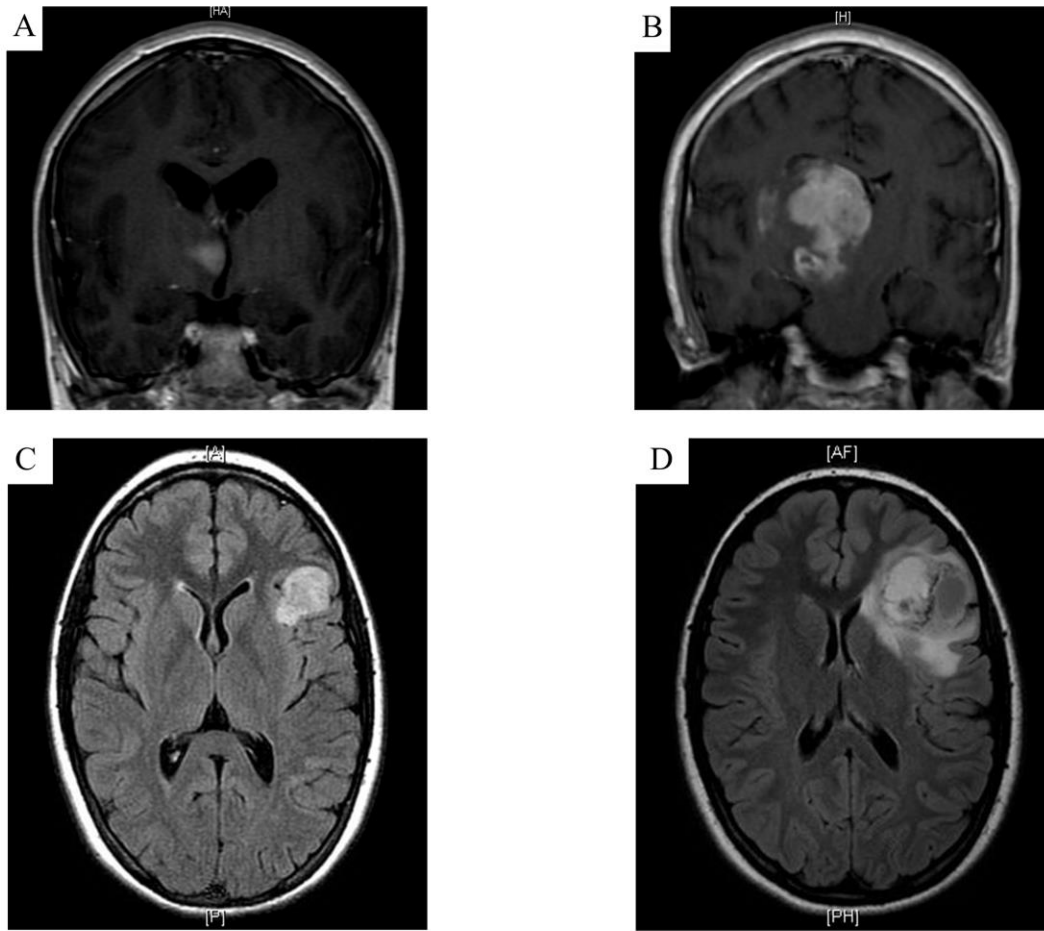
Radiological diagnosis of glioma transformation. Coronal T1 contrast imaging (A) showing small heterogeneously enhancing lesion in the right thalamic region (B) showing heterogeneously enhancing mass with progression, invasion and mass effect indicating sHGG. Low-grade pathological diagnosis was also available. T2 FLAIR axial image for patient 7 shows (C) enhancing lesion in left fronto-temporal cortex (D) Three years after showing heterogeneously enhancing progressive lesion with local invasion and edema with mass effect. Monitoring of the initial low-grade lesion throughout the 3-year latency period was conducted. High-grade pathological diagnosis was also available. Online only.
